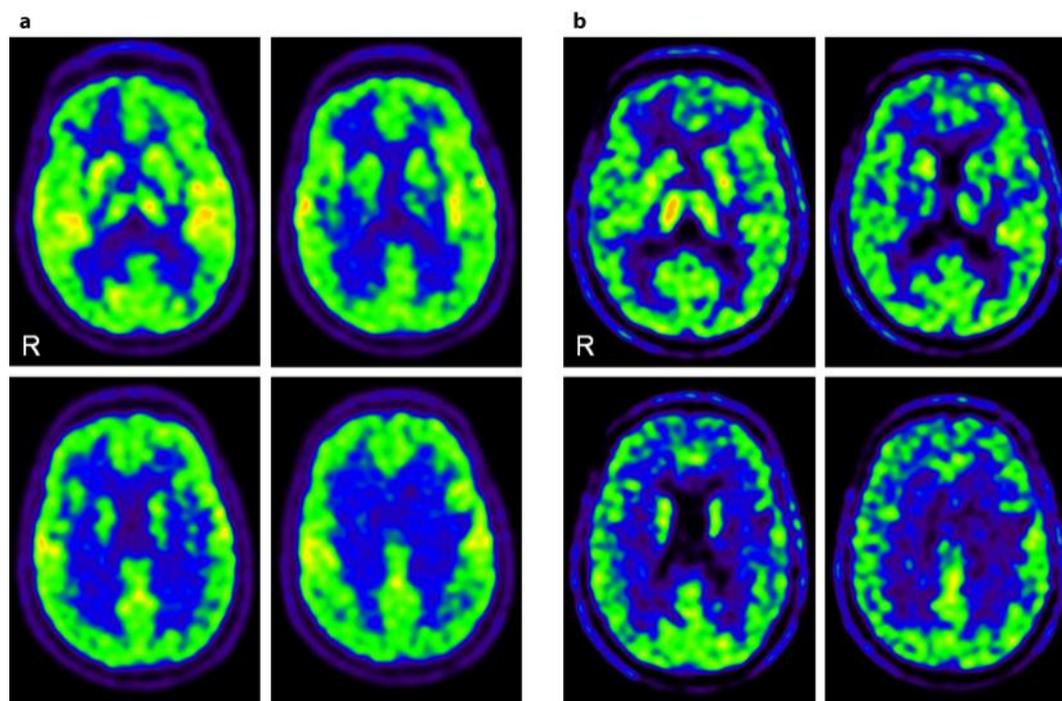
FDG-PET images showing no focally increased FDG uptake corresponding to the enhanced lesions and diffuse glucose hypometabolism in the cerebral cortex (a). MET-PET images showing no focally increased MET uptake corresponding to the enhanced lesions (b).
